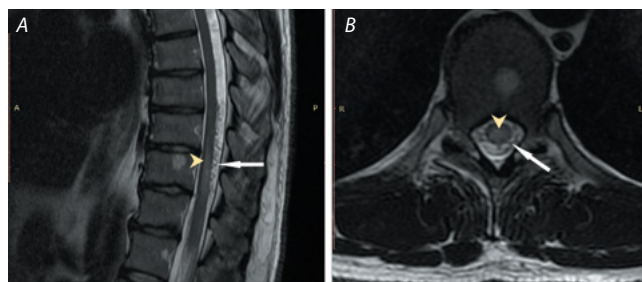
MR image of patient V. with spinal venous insufficiency at Th9–Th11.
